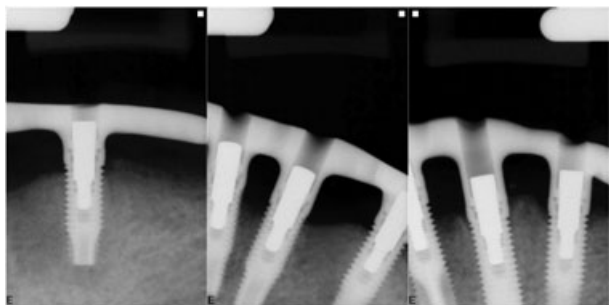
Postoperative radiograph demonstrated excellent bone/implant contact and the framework of a fixed implant-retained mandibular prosthesis.
